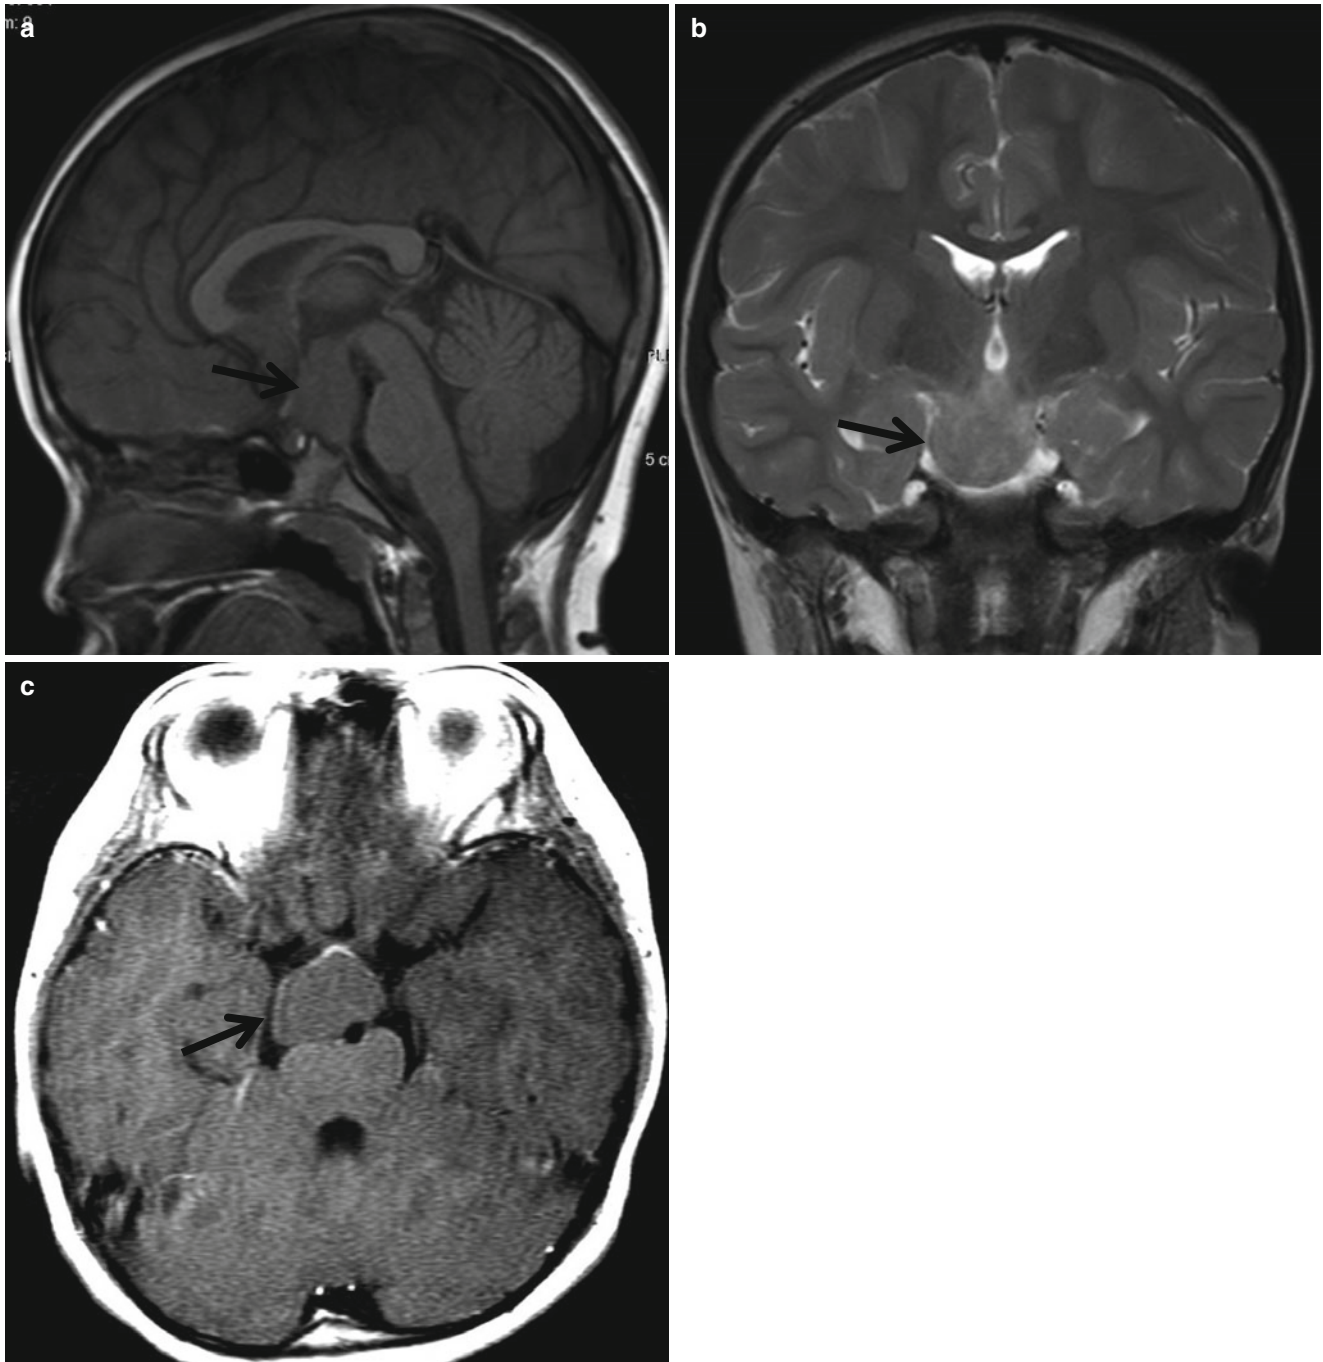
Hypothalamic hamartoma. (a) Sagittal T1-weighted image shows isointensity mass (*arrow*) attached at the tuber cinereum of hypothalamus. (b) The lesion (*arrow*) is slightly high intensity on T2-weighted image. (c) Enhancement is not seen on a postcontrast image (*arrow*)
